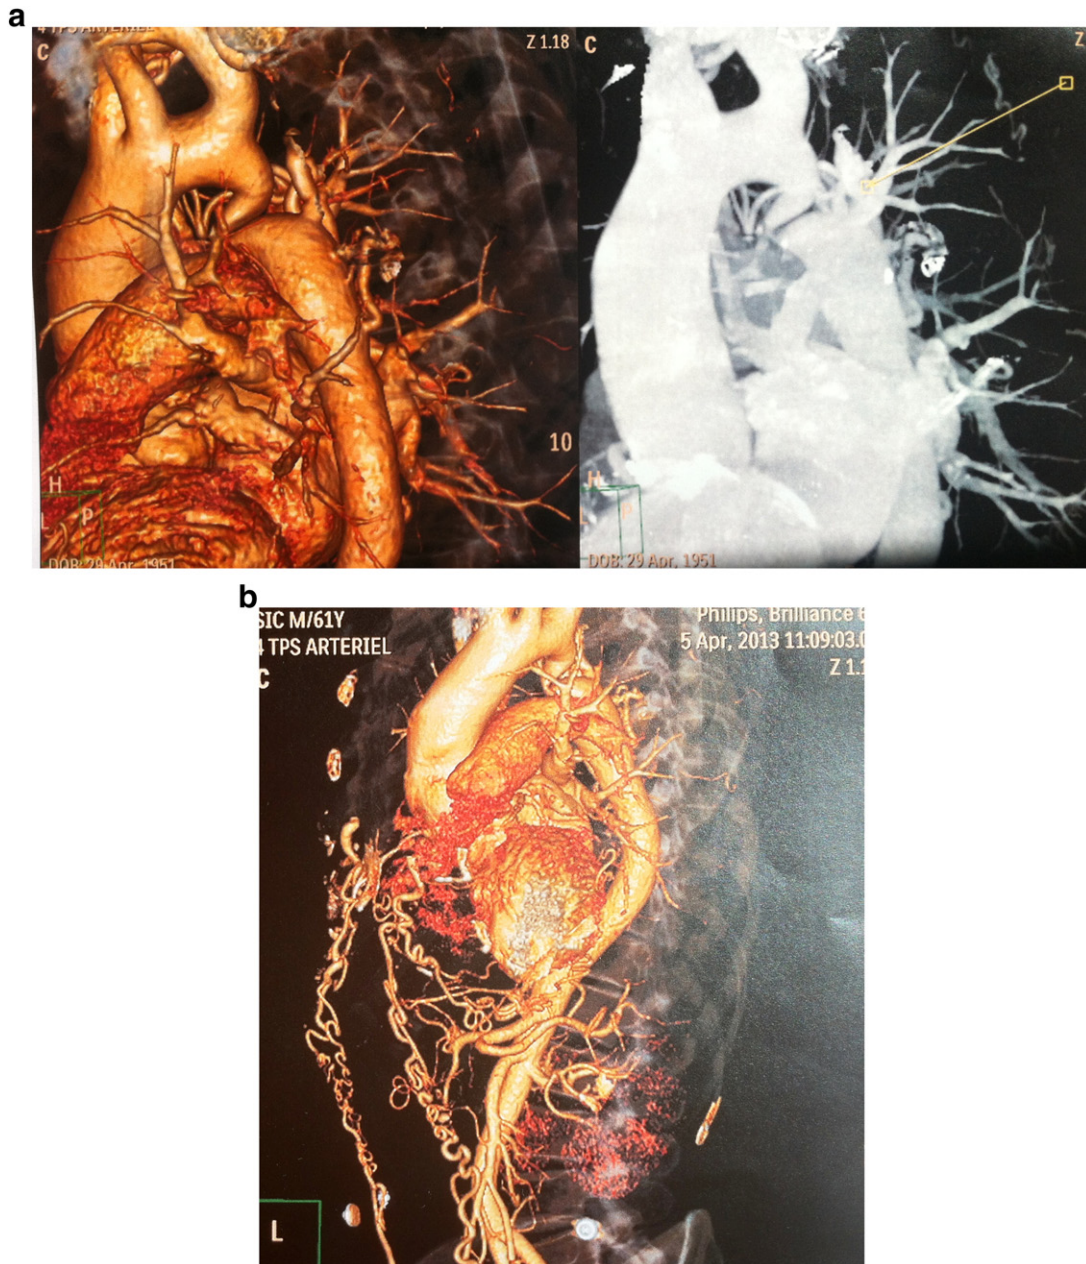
a: CT scan with 3D reconstruction (right image) showing a very severe aortic coarctation with a critical stenosis (yellow arrow) just after the take-off of the subclavian artery. b: large ascending to descending collaterals and largely developed intercostals arteries.
